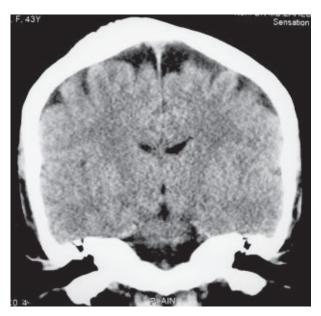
Pre-operative CT scan of brain shows calvarial meningioma without dural invasion.
